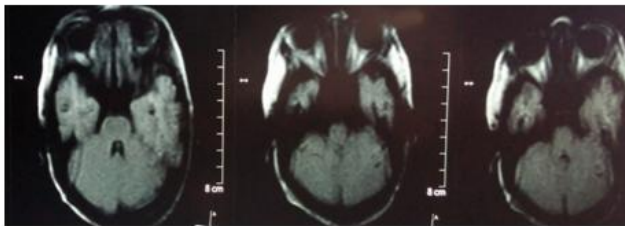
Computed tomographyscan of the brain and orbit showed stenosis of both optic canals along with optic nerve sheath dilatation
